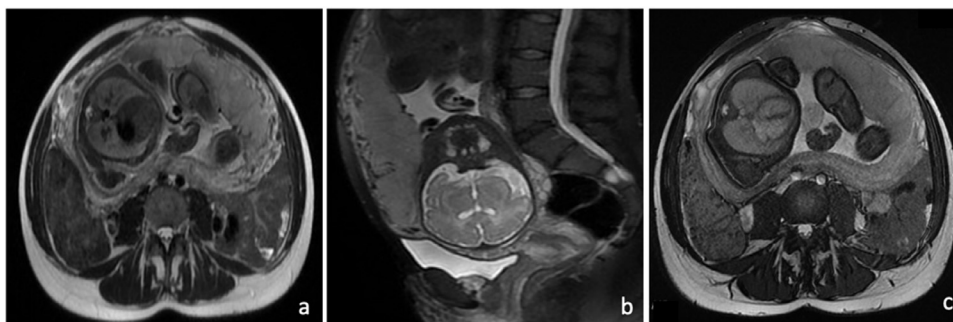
Patient with cesarean scar pregnancy with suspected accrete MRI sequences: T2 axial (a), T2 FS sagittal (b), GE axial (c).
